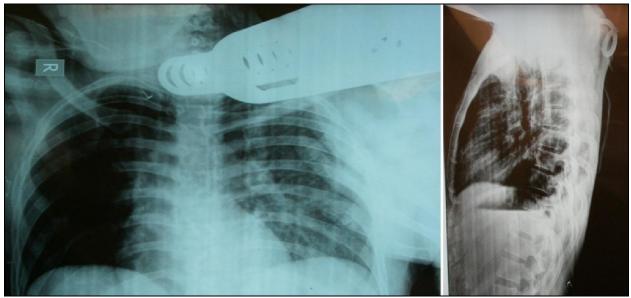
Chest X-ray; AP, lateral view and superior view
